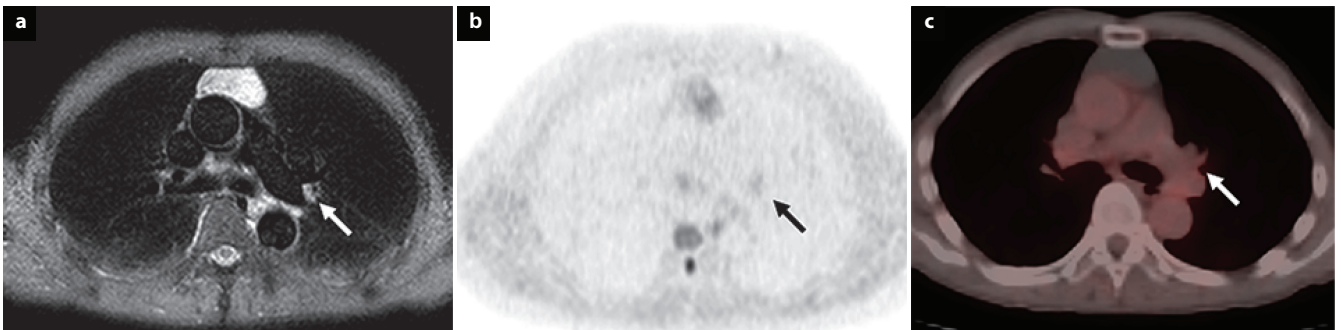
Images in a 72-year-old patient with pathologically diagnosed N1 adenocarcinoma. a: STIR turbo SE image shows that left hilar lymph node (arrow) has high SI. Primary lesion is not visible in the same axial plane. Thymic cyst can be seen in the anterior mediastinum. LSR of the lymph node was 0.70, LMR was 1.5, and visual score was 5. An accurate diagnosis of N1 disease was made. b: DW MR image shows that left hilar lymph node (arrow) has low SI. Primary lesion is not visible in the same axial plane. Thymic cyst can be seen as low SI in anterior mediastinum. ADC of the lymph node was $1.5 \times 10^{-3} \text{sec/mm}^2$, and visual score was 2. An inaccurate diagnosis of N0 was made. c: FDG PET/CT image shows that left hilar lymph node (arrow) has low uptake of FDG. Primary lesion is not visible in the same axial plane. Thymic cyst can be seen in the anterior mediastinum. SUV_{max} of the lymph node was 1.2, and visual score was 1. An inaccurate diagnosis of N0 disease was made. (Reproduced, with permission, from reference No. 99) ADC, apparent diffusion coefficient; DW, diffusion-weighted; FDG, fluorodeoxyglucose; LMR, lymph node-to-muscle ratio; LSR, lesion-to-spinal cord ratio; PET, positron emission tomography; SE, spin-echo; SI, signal intensity; STIR, short inversion time inversion recovery; SUV_{max} , maximum standardized uptake value.
